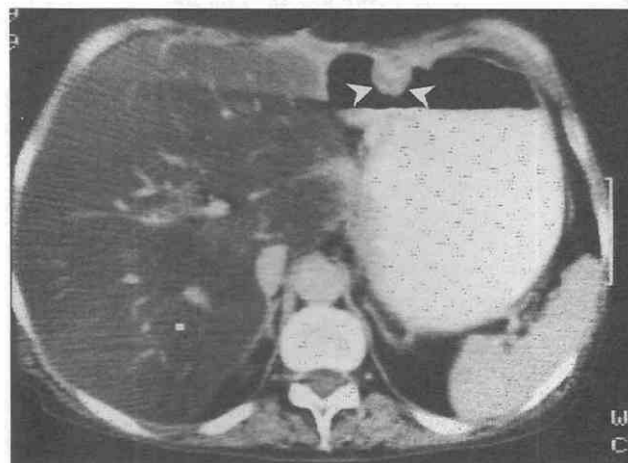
Tumor recurrence at the surgical plication. CT scan shows prominent surgical plication (arrowheads). Surgery confirmed tumor infiltration at the plication. (From Ha HK, Kim HH, Kim HS, et al: Local recurrence after surgery for gastric carcinoma: CT findings. *AJR Am J Roentgenol* 161:975-977, 1993.)
